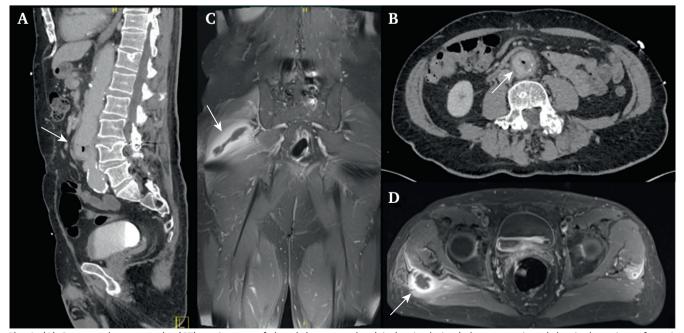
(A) Computed tomography (CT) angiogram of the abdomen and pelvis (sagittal view) demonstrating abdominal aortic graft periluminal soft tissue density thickening with slight stranding, and a small focus of gas centrally. (B) Axial view of the CT angiogram. (C) Magnetic resonance imaging (MRI) showing a chain of abscesses within the right gluteal region, in particular, the interface between the right gluteus medius and maximus. There is intense associated inflammatory oedema and enhancement. (D) Axial view of the MRI.
